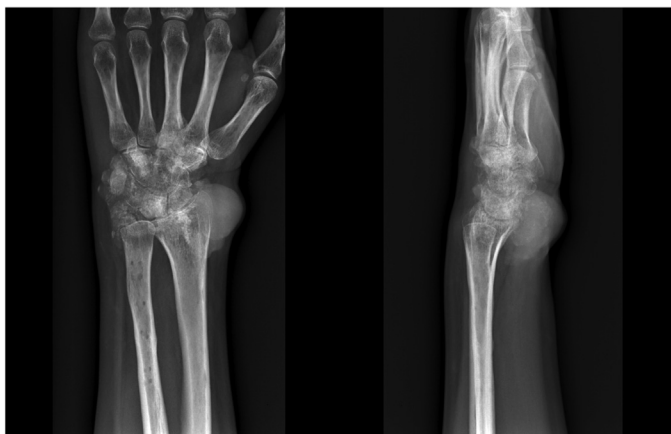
Radiographic image. Radiograph of the patient's left wrist at admission. The image shows severe calcification and destructive arthritic changes throughout the wrist joint and a large mass-like lesion on the volar side.
